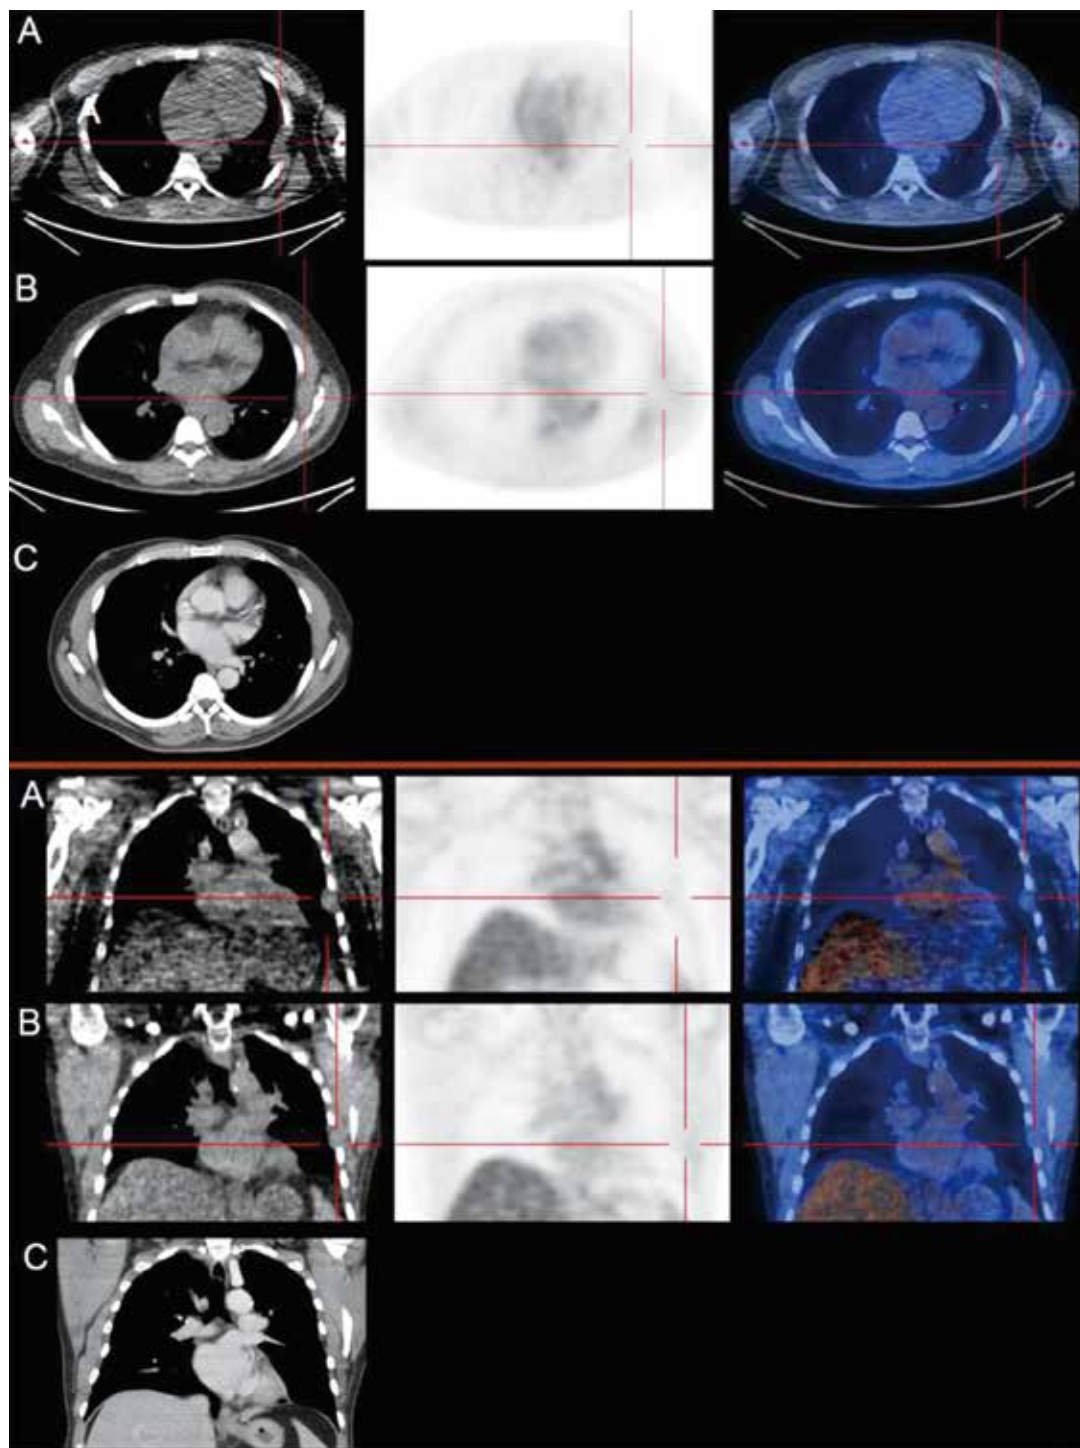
Case 1: Axial (upper) and coronal (lower) positron emission tomography/computed tomography (PET/CT) images and diagnostic chest CT image. PET/CT images obtained with the arms positioned downward and during tidal breathing (A) show a mass (red crosshair); corresponding delayed images obtained with the arms positioned upward and during tidal breathing (B) shows that the lesion decreased in size and retreated into the fifth intercostal space. This mass does not show fluorodeoxyglucose uptake. Diagnostic chest CT (C) shows no abnormality at this site.
